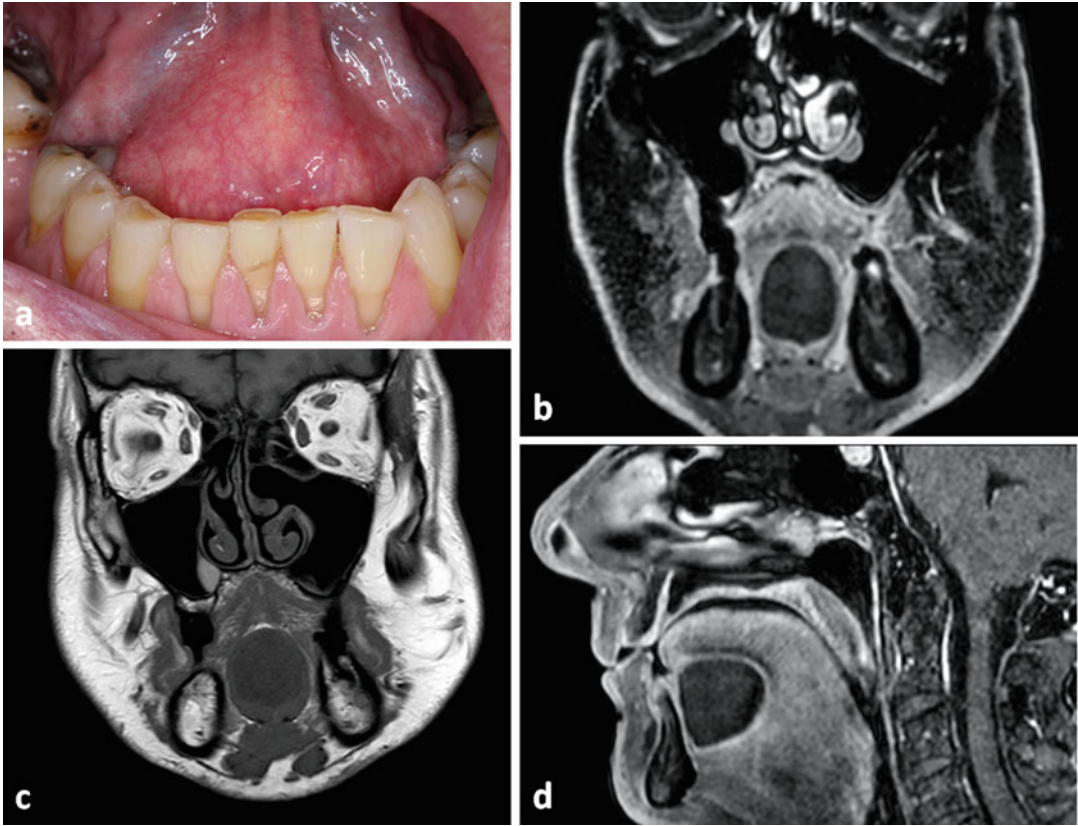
Epidermoid cyst presenting as a soft tissue fluctuant mass in the anterior floor of mouth with no symptoms (a). MRI T1 coronal (b) and post-gadolinium coronal (c) and sagittal (d) views show a well-defined ovoid lesion within the floor of the mouth splaying the geniopharyngeal and genioglossus muscles and which measures 27 mm
